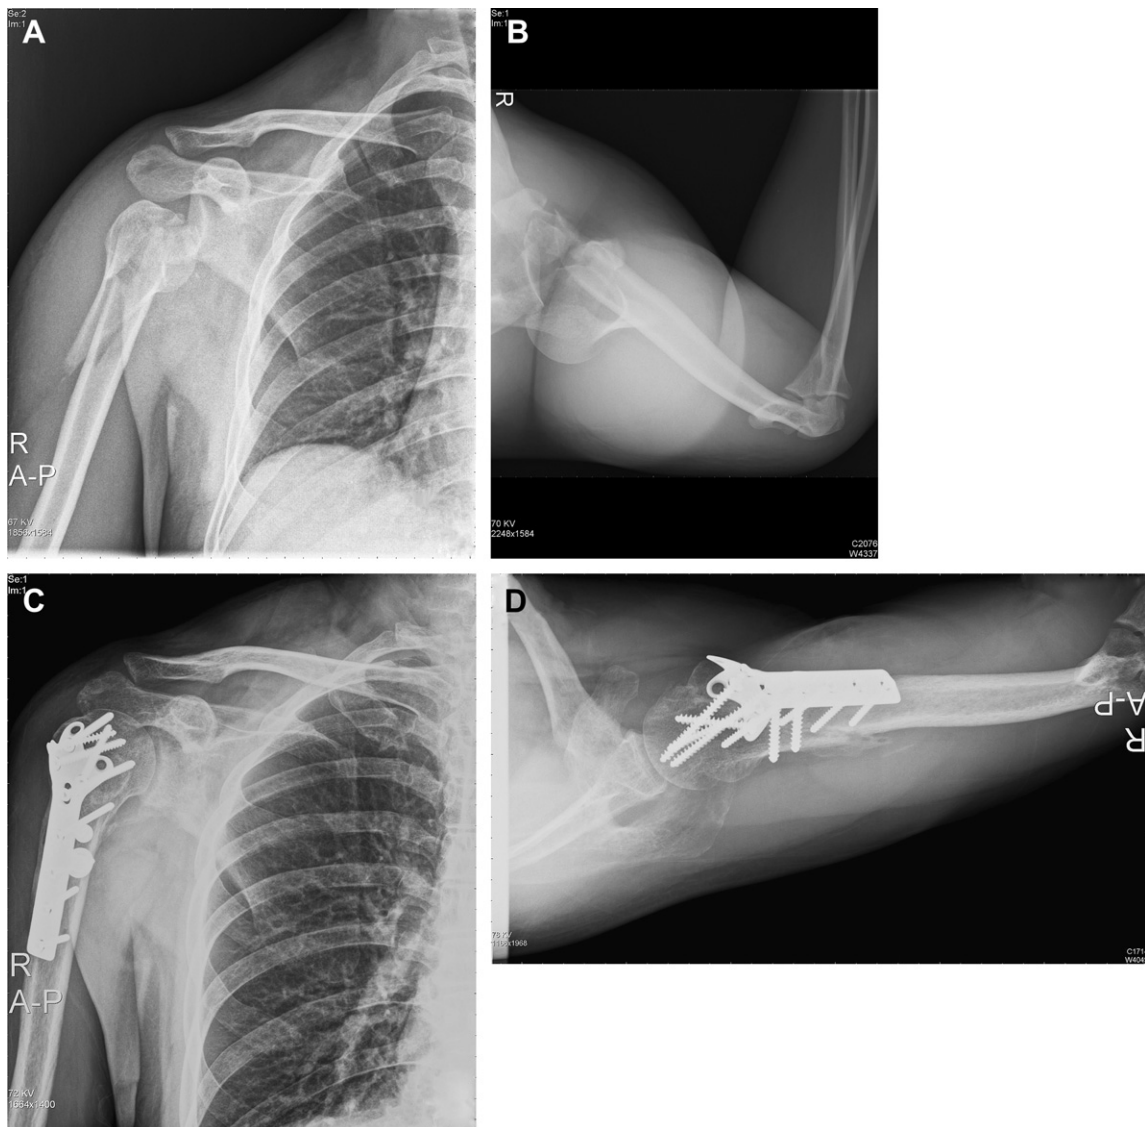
A 33-year-old man underwent open reduction and internal fixation for a three-part fracture dislocation of the right proximal humerus at 1 month after his injury because of a concomitant injury (A and B). Radiography performed at 1 year after the surgery revealed union of the fracture site (C and D). He retained full range of motion and function of the right shoulder.
